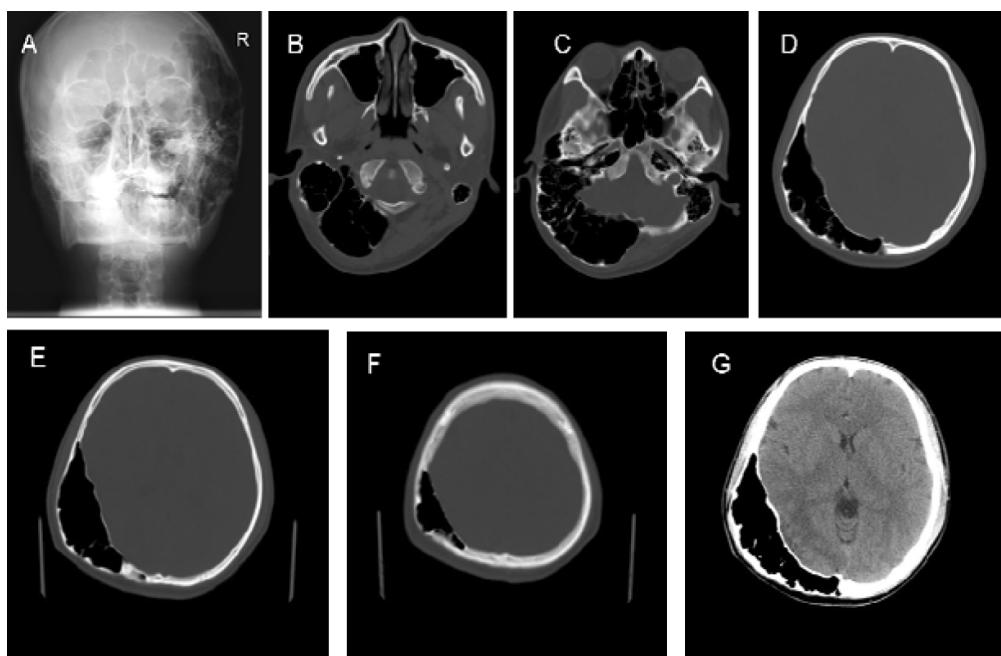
24岁男性,因“头外伤”要求影像学检查。头颅正位片显示右侧颞骨及顶骨局部膨隆,呈多发边界清楚的低密度区(A)。头颅 CT 骨窗自颅底向上层面(B-F)显示右侧颞骨、部分顶骨及枕骨多发边界清楚含气透亮区，骨皮质菲薄但尚光整。头颅 CT 脑窗显示右侧大脑半球颞、枕叶界面内移,体积变小。图 A 中 R 示右侧
